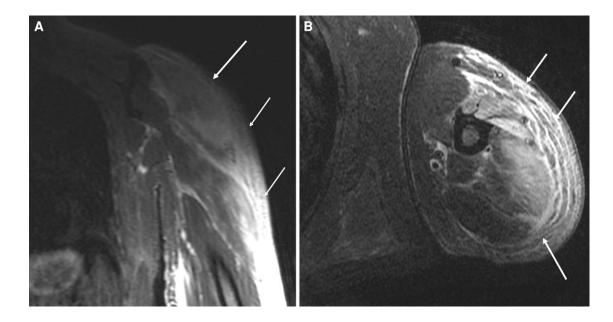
Coronal (*A*) and axial (*B*) magnetic resonance imaging short T1 inversion recovery images showing extensive myositis involving the left deltoid, triceps, and (less extensively) brachioradialis musculature with surrounding edematous signal intensity (arrows) and enlargement of the visualized proximal upper extremity.
